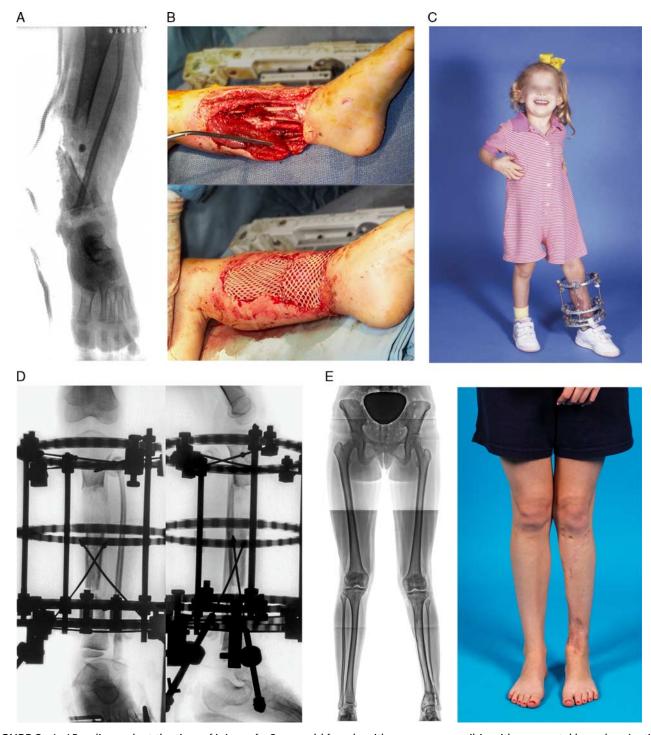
A, AP radiograph at the time of injury of a 3-year-old female with a severe open tibia with segmental bone loss (patient #1 in Table 1). B, Clinical photograph at the time of soleus flap and skin grafting. C, Clinical photograph with initial frame stabilization to allow bone transport. D, AP and lateral radiographs at conclusion of bone transport. E, Final standing AP radiograph and clinical appearance after multiple procedures for physeal arrest including a secondary lengthening and eventual Achilles tendon lengthening.
